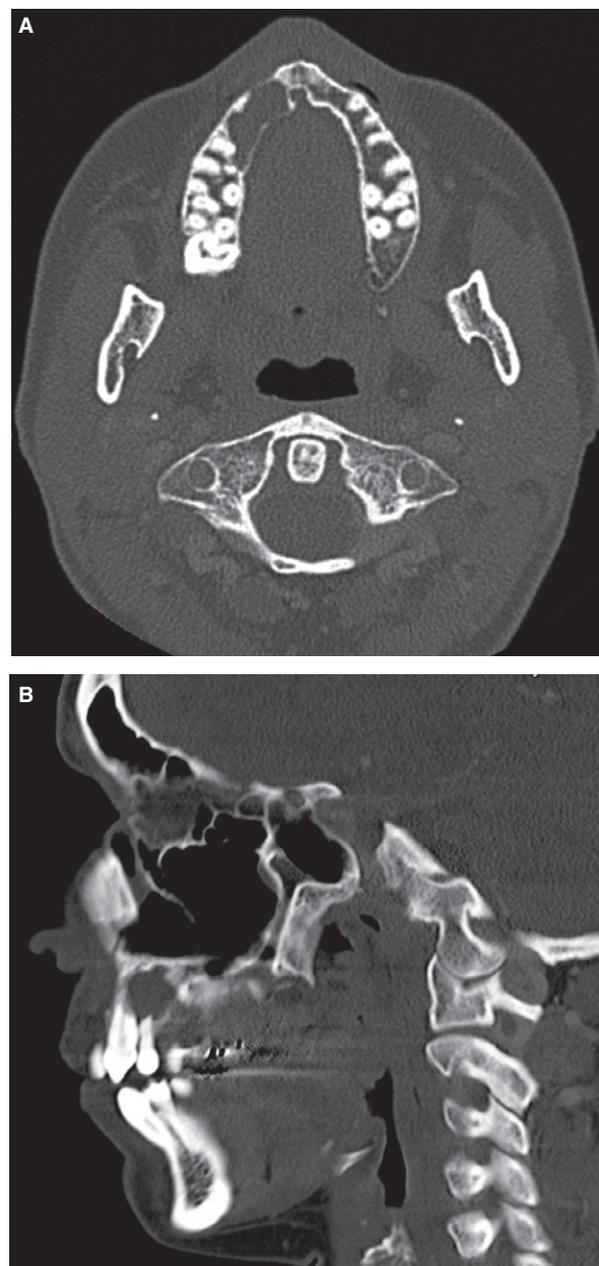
(A) Axial computerised tomography (CT) scan demonstrating a radiolucent lesion occupying the right anterior maxilla with cortical thinning and erosion. (B) Sagittal CT showing the lesion extending into the floor of the nose, invading the palatal soft tissue and eroding the roots of involved teeth.
